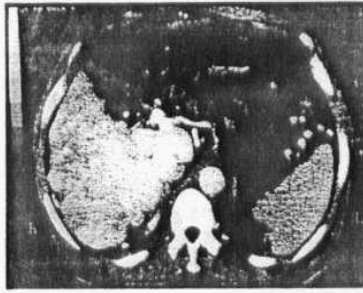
CT hepatic artery angiography showed uneven distribution of the contrast through the liver parenchyma.
